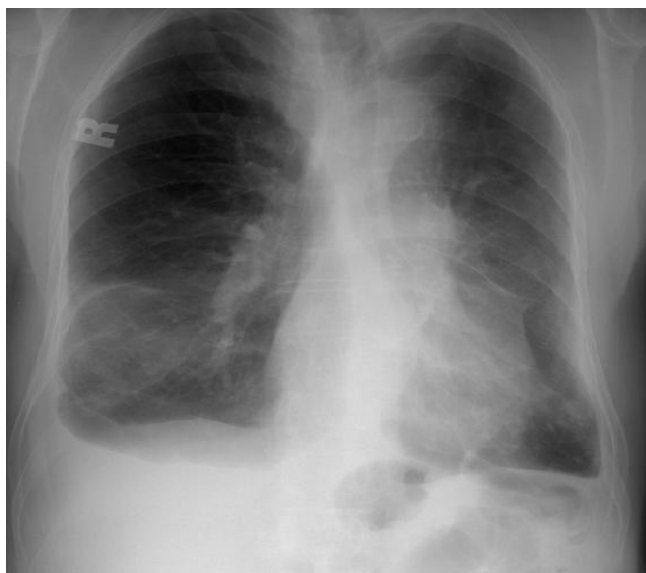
The x-ray showing regressed right-sided pleural effusion.
